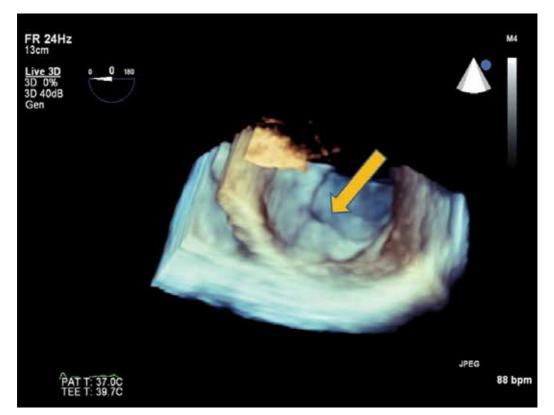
Real time 3D transoesophageal echocardiogram of a left ventricular apical thrombus (arrow)
